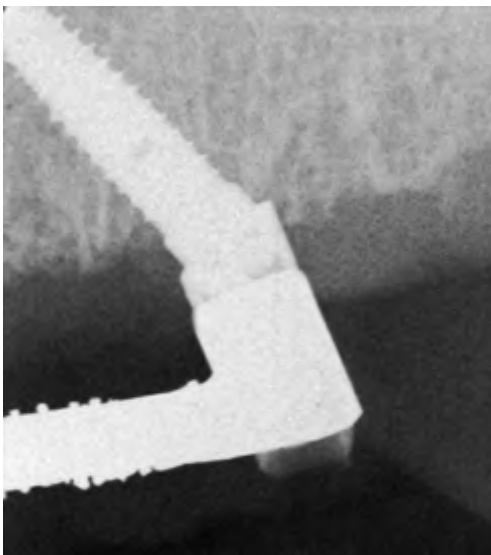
Periapical radiograph of the left distal implant/abutment/cylinder interface that demonstrated an accurate fit between the implant components. There was a retaining screw in the right distal portion of the prosthesis (not pictured). Per the Columbus Bridge Protocol, the framework was not cantilevered distal to the last implant.
